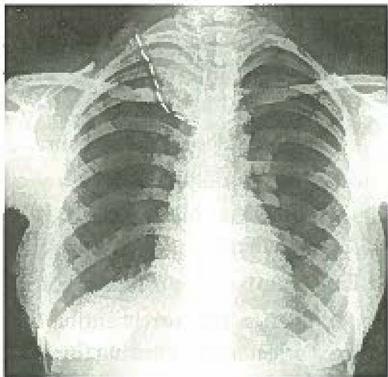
X-ray showing collapse right upper lobe with consolidation and CT Chest showing collapsed lung
